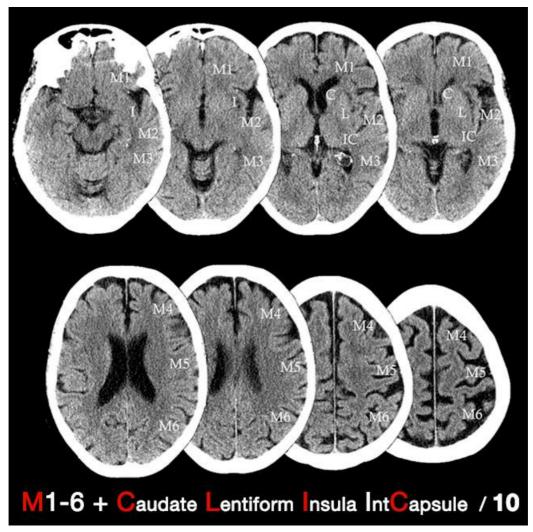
ASPECTS scoring at the ganglionic and supraganglionic level.
